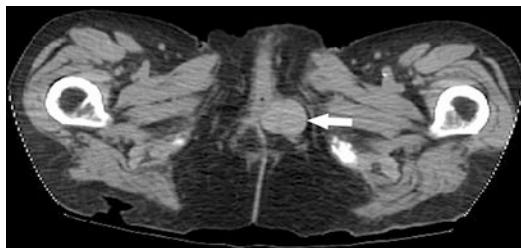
CT image of the pelvis of a 62-year-old with an incidentally discovered hyperdense Bartholin gland cyst on the left (arrow). It is important to ensure there is no solid component, and not to confuse this with a vulvar malignancy
